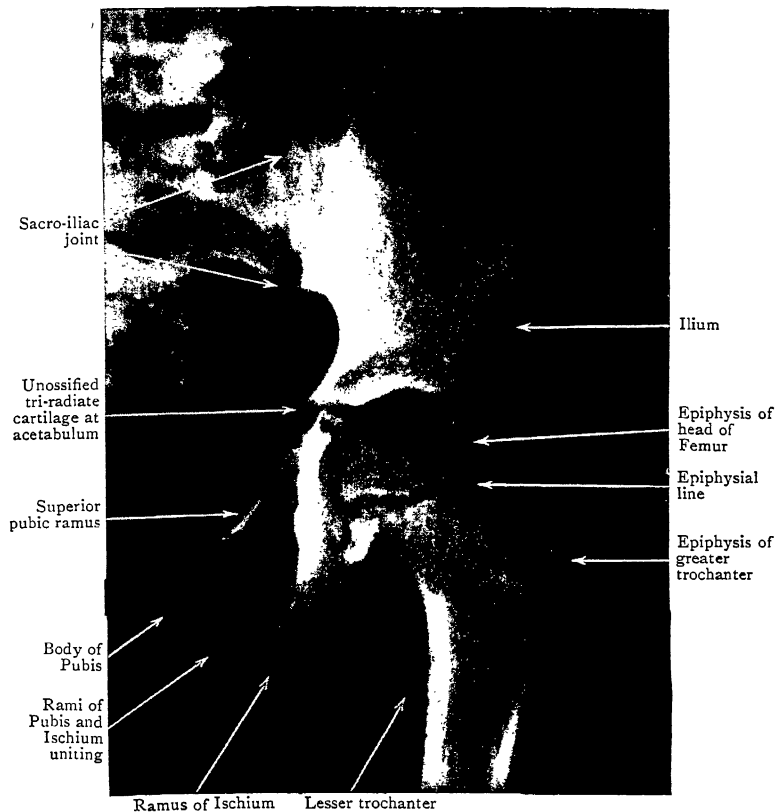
Radiograph of Hip of boy aged 7.
